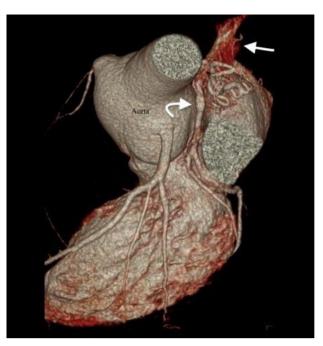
Cardiac 3D image obtained by Multidetector Computed Tomography (a) shows that the left circumflex artery (curved white arrow) originates from the pulmonary artery (white arrow) and then travels in the left atrioventricular groove. The hyperdense appearance in the oblique reformat image (b) where the left circumflex artery (star) opens to the pulmonary artery (black arrow) indicates that the flow in the left circumflex artery is towards the pulmonary artery.
